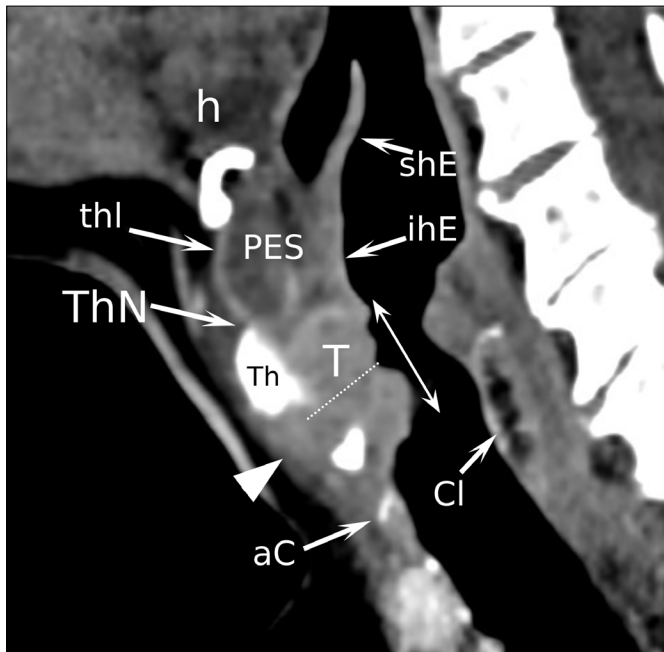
Sagittal CT showing a vertical trans-AC tumour (T) with cranial extension to the infrahyoid epiglottis (ihE), pre-epiglottic space (PES), and full-thickness invasion (white arrowhead) of the thyroid cartilage (Th) at the level of the AC (dotted line). h: hyoid bone; shE: suprahyoid epiglottis; thl: thyro-hyoid ligament; ThN: thyroid notch; aC: anterior arch of the cricoid; Cl: cricoid lamina.
